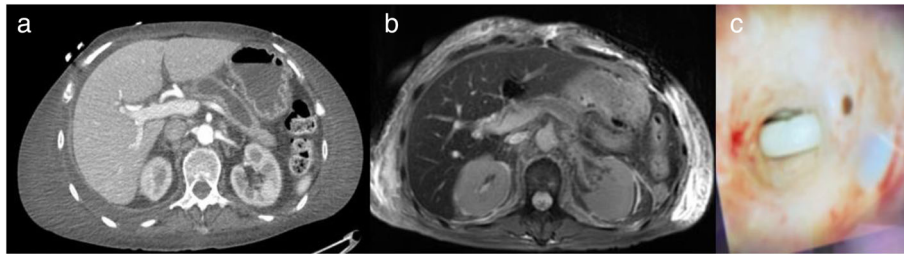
(a) CT of abdomen showing pancreatic duct (PD) dilatation 3 months prior to this admission. (b) MRI of abdomen showing resolution of PD dilatation on this admission after repositioning. (c) SpyGlass image showing the plastic stent in the PD.
